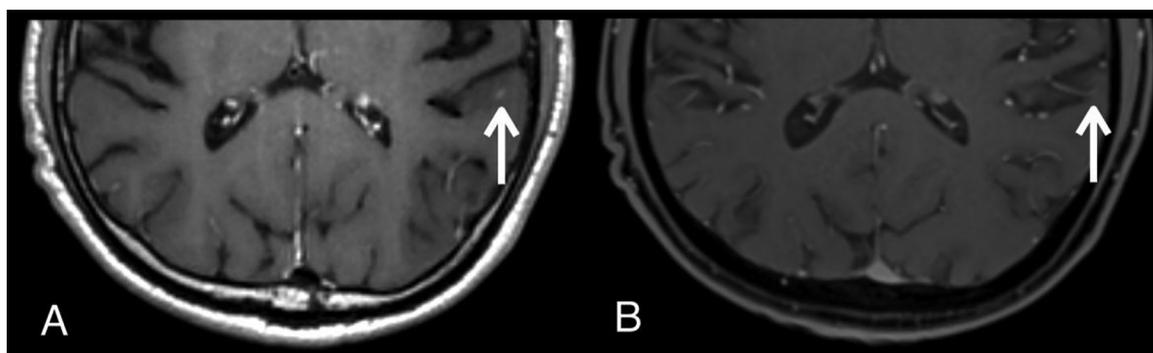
A 62-year-old lung cancer patient with a false-positive lesion in the left temporal lobe (white arrow). Axial contrast-enhanced 3D T1-weighted SPACE (A) and contrast-enhanced 3D T1-weighted VIBE (B). A false-positive lesion is a partial hyperintensity of a blood vessel which mimics enhancing brain metastasis on contrast-enhanced 3D T1-weighted SPACE (A). The linear hyperintensity continues as a vascular structure on contrast-enhanced 3D T1-weighted VIBE (B).
